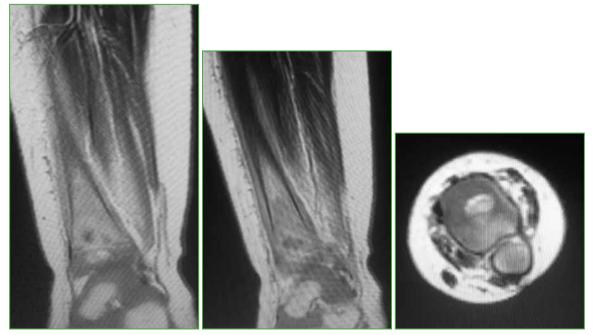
Left ankle sagittal and axial MRI sections.
